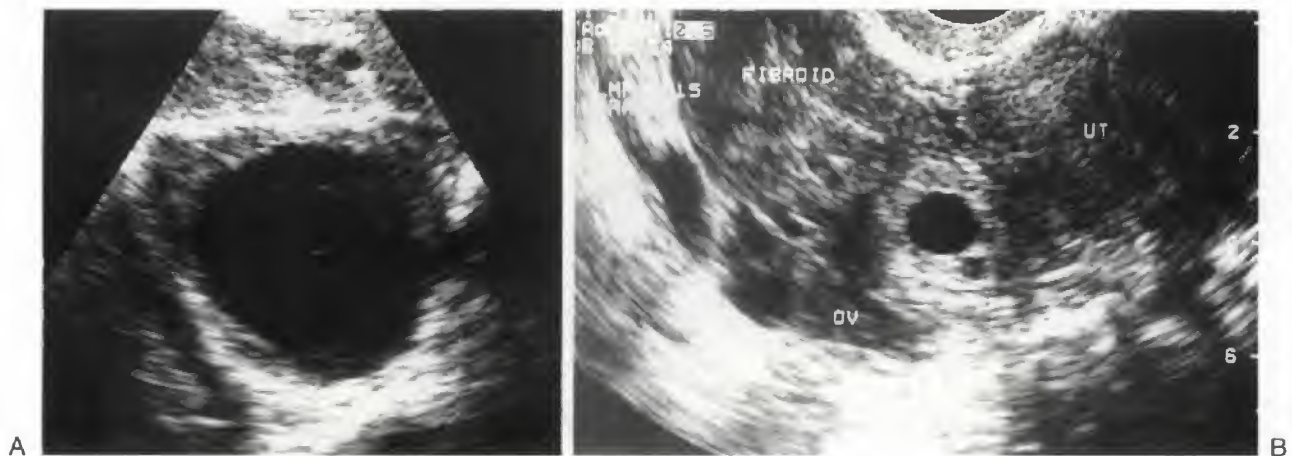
Transvaginal scan in a patient suspected of harboring an ectopic pregnancy. A. Sagittal transvaginal color Doppler image of a 2-cm thick-walled hemorrhagic cyst. Note the central fibrin strand mimicking a yolk sac (arrow). Note the ring of fire appearance to the cyst. B. Transverse, transvaginal image shows that the mass (arrows) is located within the ovary (arrowheads). Additional images (not shown) demonstrated an intrauterine gestational sac with yolk sac. Even in a patient with no visualized intrauterine pregnancy, an ovarian mass is more likely to represent a hemorrhagic corpus luteal cyst than an ovarian ectopic. In this case, the hemorrhagic cyst resolved on follow-up. (From Swire MN, Castro-Aragon I, Levine D: Various sonographic appearances of the hemorrhagic corpus luteum cyst. *Ultrasound Q* 20:49, 2004.)
